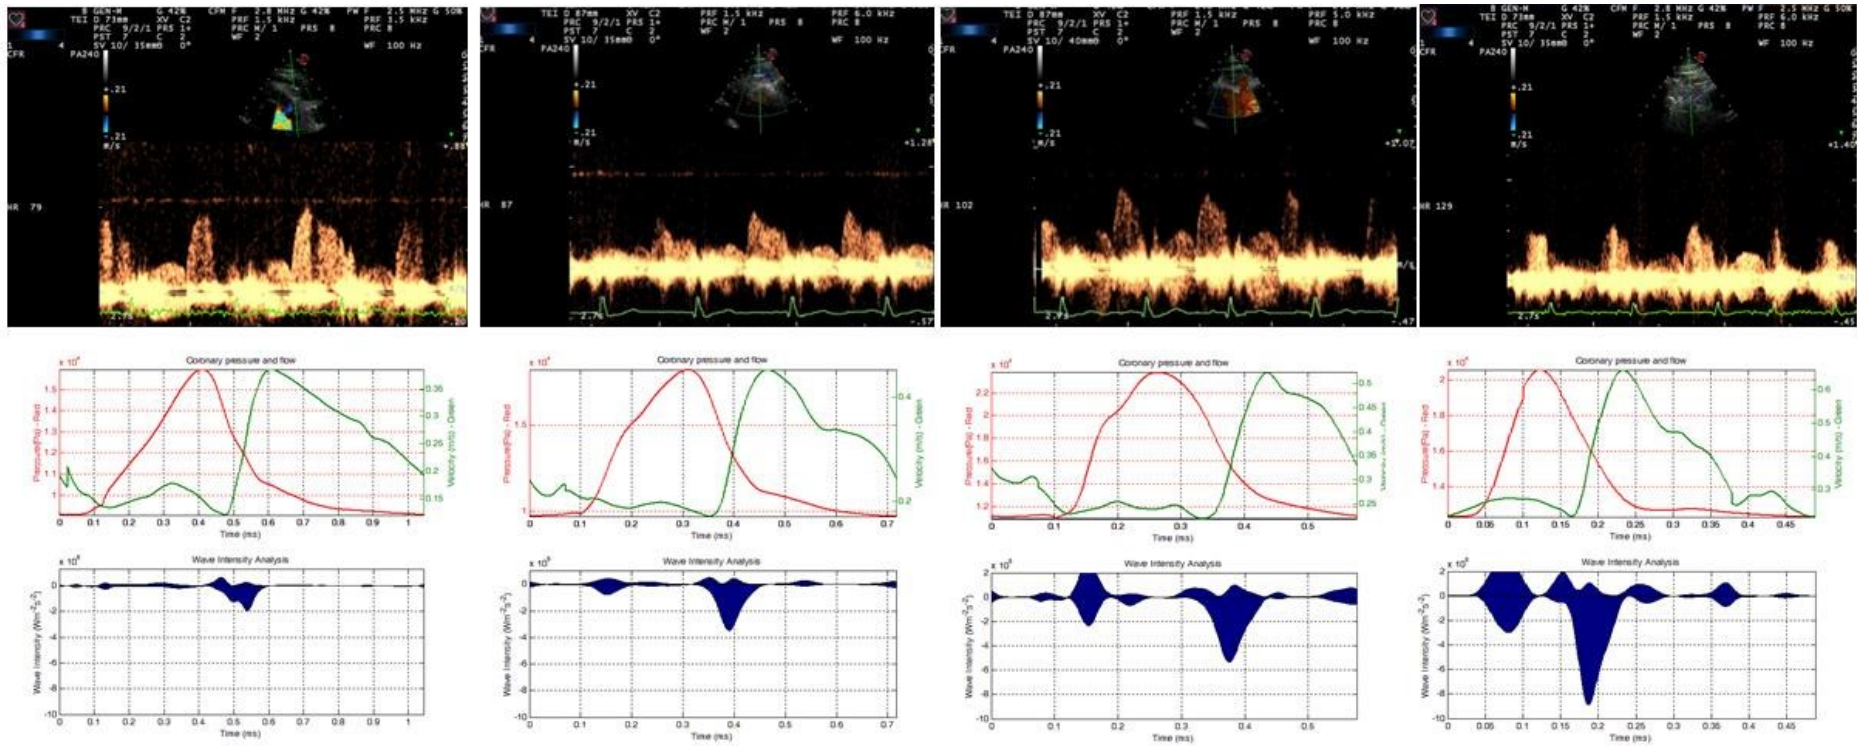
Coronary flow as measured by echocardiography with increasing heart rate with patient exercising on dedicated echo-exercise bike.
